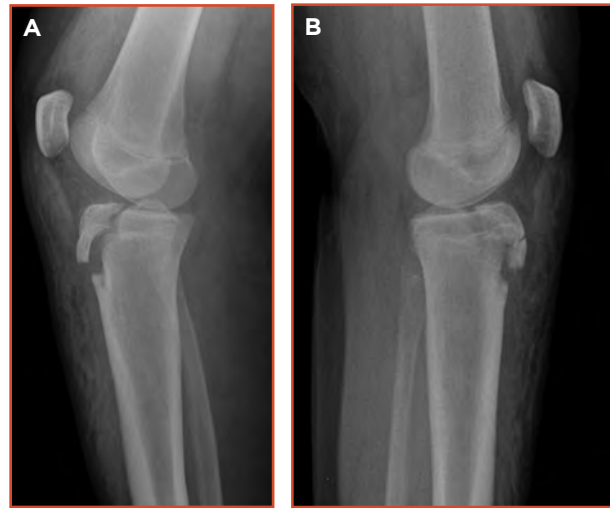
Radiographs of the A) right and B) left knees, showing avulsion fractures of the tibial tuberosity in both knees.
